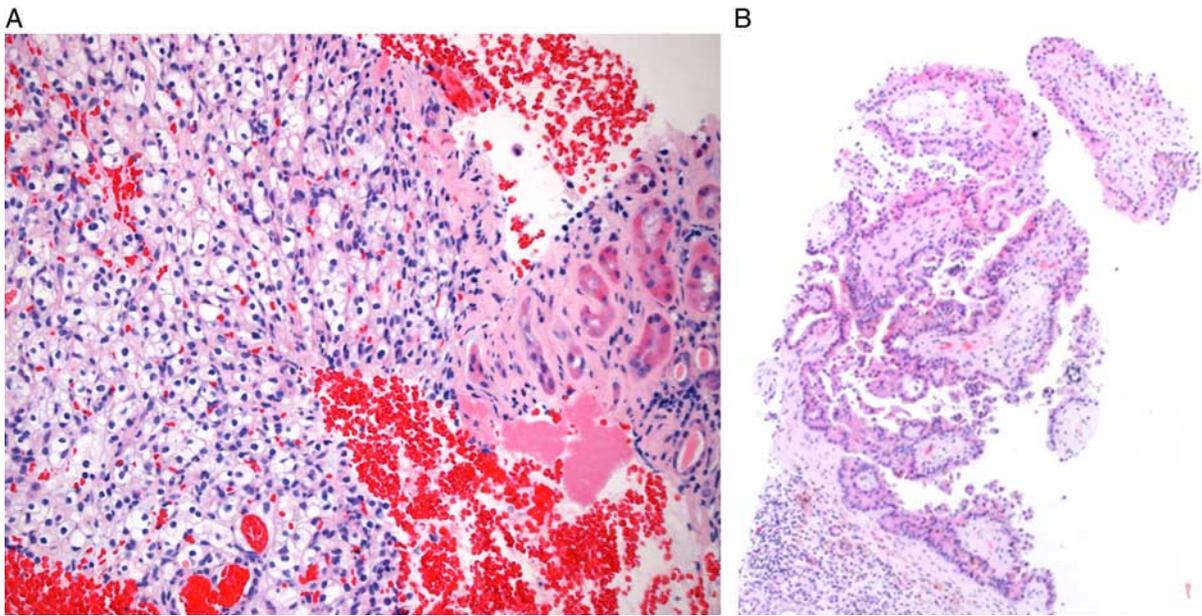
A, This is a typical clear cell renal cell carcinoma incidentally discovered on biopsy that was subsequently shown to part of a mass lesion. B, This is a probable papillary renal cell carcinoma. It is intermediate grade and has a fibrous pseudocapsule. I would diagnose as papillary neoplasm, intermediate grade, favor papillary carcinoma and encourage imaging studies. If ultrasound performed at the time of biopsy showed a mass I would diagnose as papillary renal cell carcinoma.
